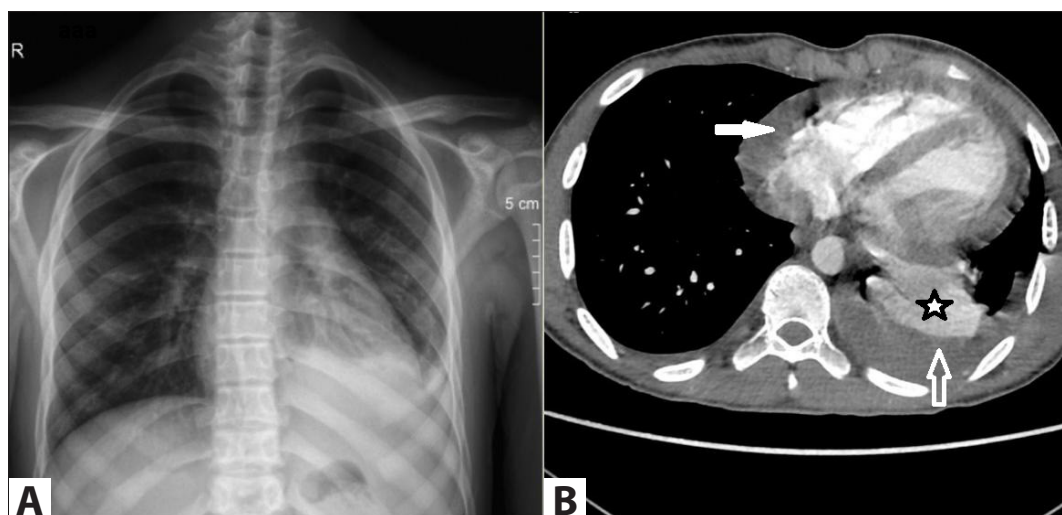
A. Chest radiography shows the appearance of pleural effusion on the left. B. Thorax CT scan shows pericardial (white arrow) and left pleural effusion (hollow arrow). There is also compressive atelectasis in the lower lobe of the left lung adjacent to the effusion (asterisk).
